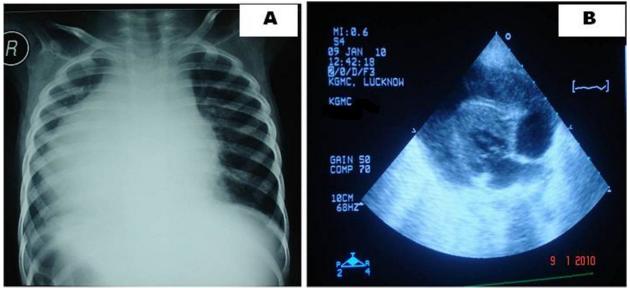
(a) CXR showing dextrocardia with cardiomegaly (b) Echocardiogram confirmed dextrocardia with 1.6 cm circumferentially thick and organized pericardial fluid
